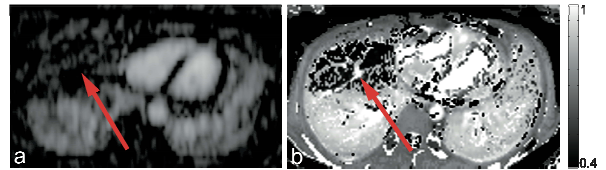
A patient with pneumonia; (a) Dynamic contrast enhanced MRI subtraction image; (b)  $fPBV$  map of a comparable slice
